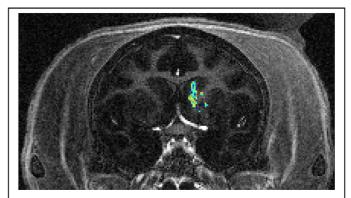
Contrast enhanced T_{I} -w MR image obtained after 30 min of sonication (background image, grayscale) overlapped by the segmented image (BBB opening, color) resulting from the absolute difference between the baseline image and the background image.
